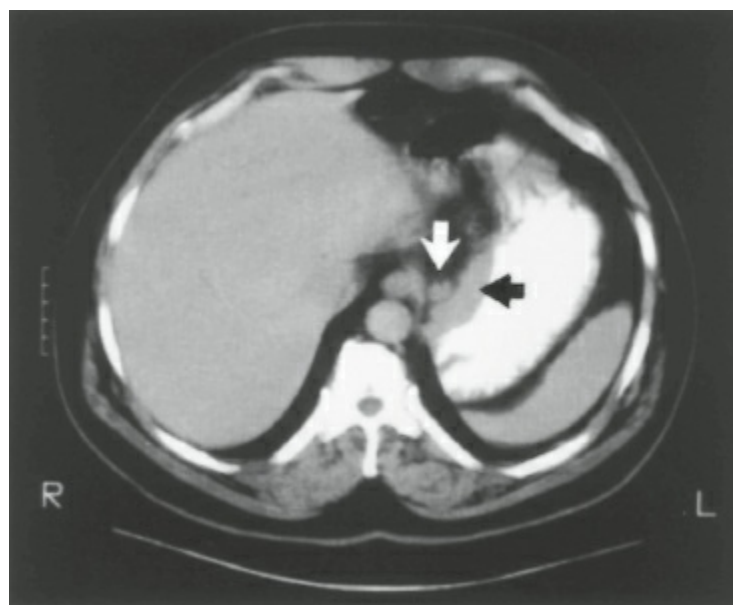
Computed tomography scan demonstrating mass along lesser curvature of the stomach (*black arrow*) and associated lymph node enlargement (*white arrow*).
